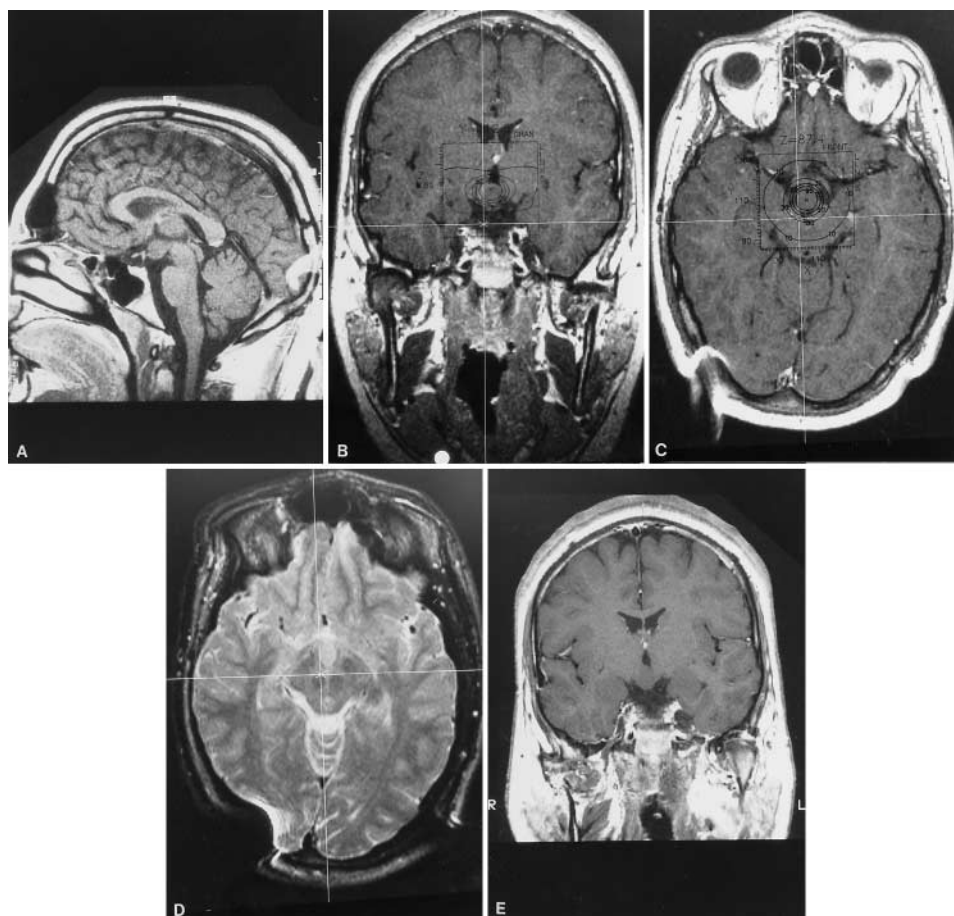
Case 1. A: Gadolinium-enhanced T₁-weighted sagittal MR image obtained in a 13-year-old boy with a sessile hypothalamic hamartoma measuring 13 mm in diameter. The lesion appears isointense in relation to gray matter before radiosurgery. B and C: Gadolinium-enhanced T₁-weighted coronal (B) and axial (C) MR images obtained for gamma knife planning. D: A T₂-weighted axial MR image obtained for gamma knife planning demonstrating increased signal intensity. E: Gadolinium-enhanced T₁-weighted coronal MR image obtained 50 months after radiosurgery. The tumor remains unchanged in size.
